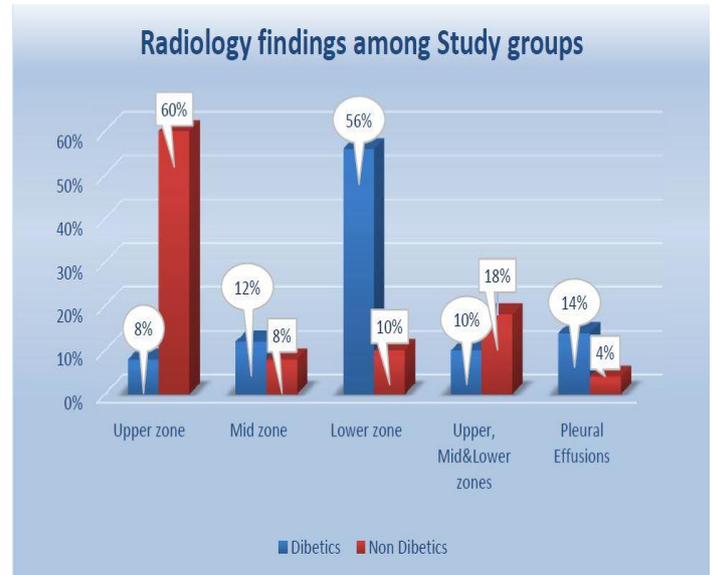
Zonal involvement on chest X-ray among diabetics and non-diabetic tuberculosis patients.
